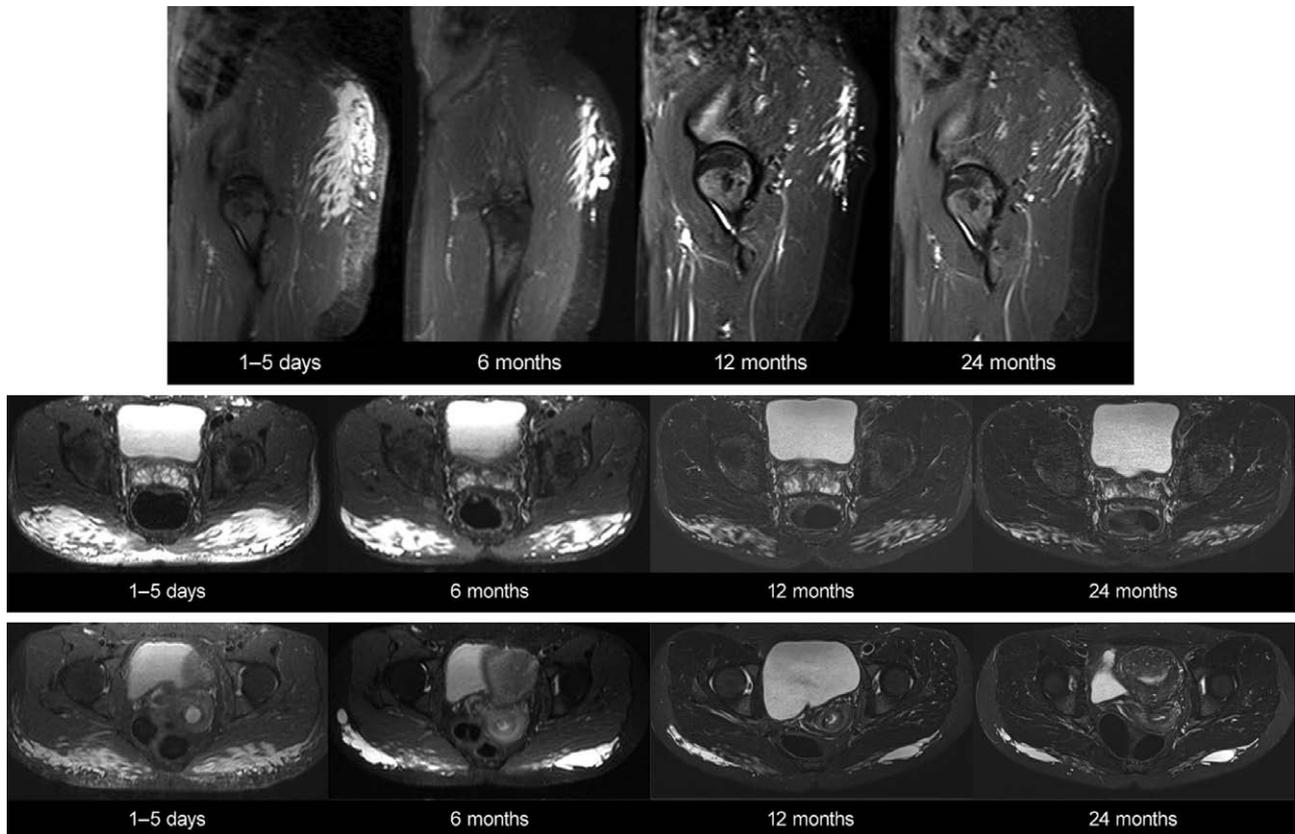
Magnetic resonance imaging scans of nonanimal stabilized hyaluronic acid gel within the buttocks. (*Above*) Sagittal short T1 inversion recovery images: some of the gel is inside the gluteal muscle in a feather-like distribution. The majority of the gel is in a globular subcutaneous pattern. (*Center*) Transverse short T1 inversion recovery images. Nearly all of the gel is in the subcutaneous space, with continuous degradation. (*Below*) Transverse short T1 inversion recovery images. More than 50 percent of the gel is inside the gluteal muscle in a feather-like distribution. The rest is in a globular subcutaneous pattern. The gel inside the muscle is degraded faster.
